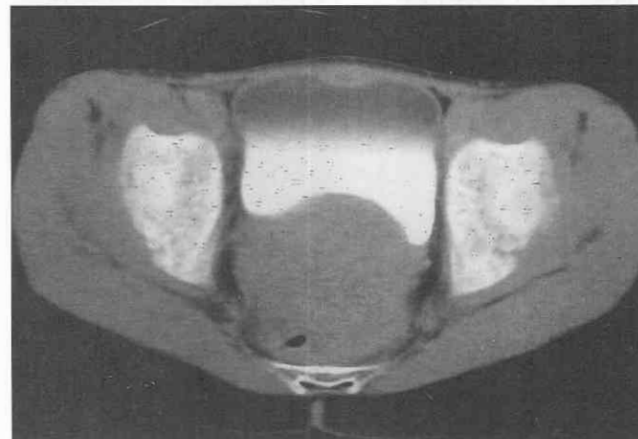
Drop metastasis into the pouch of Douglas. CT scan through the pelvis shows a large drop metastasis in the pouch of Douglas.
